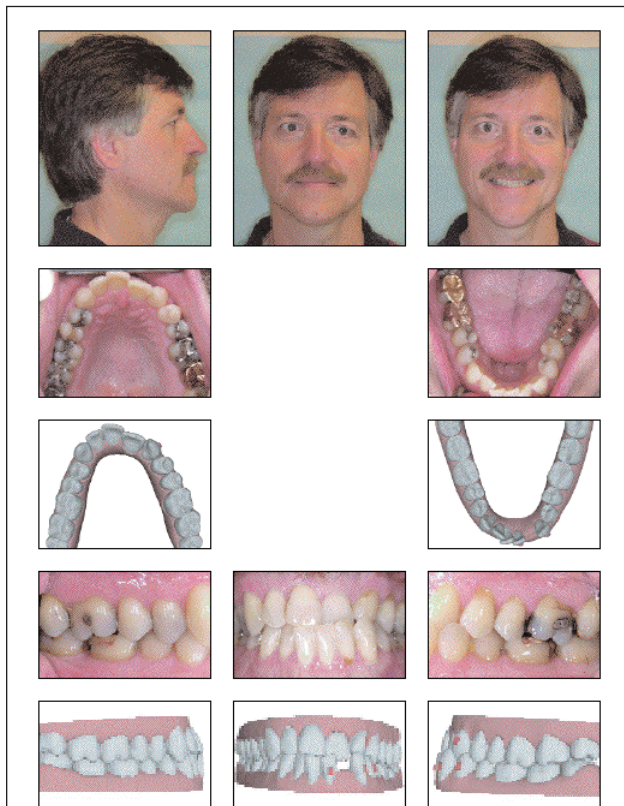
This patient presented with a Class III malocclusion, edge-to-edge bite, severe crowding in the lower arch and moderate crowding in the upper. Also, the maxillary left lateral was missing. In the transverse dimension it can be seen that the anterior teeth are in Crossbite and the midlines are significantly off. There were no radiographic findings to contradict orthodontic treatment.
